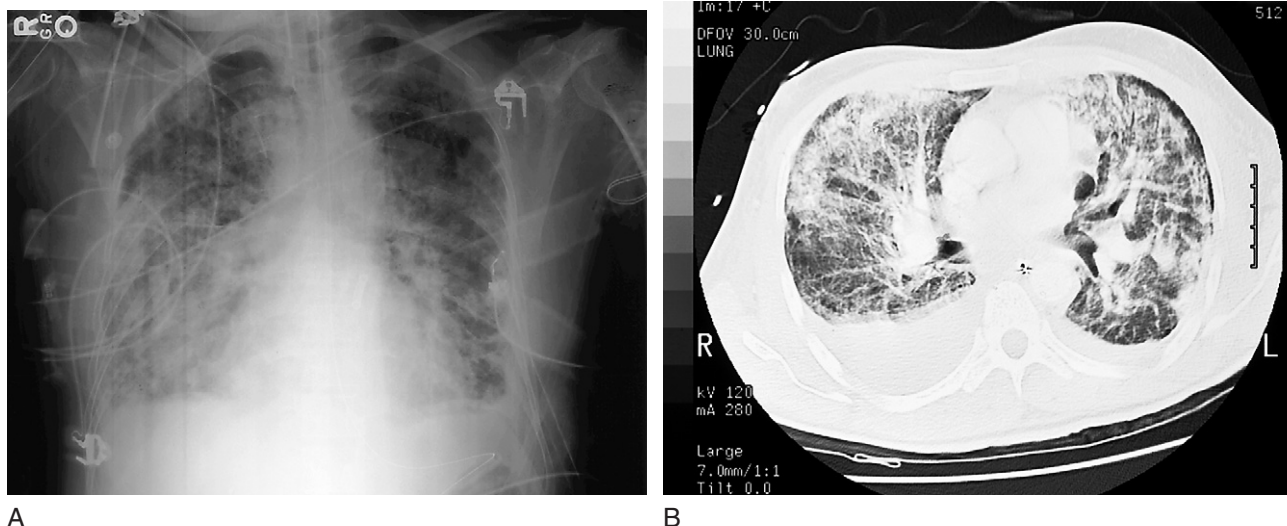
A, The chest radiograph of a 64-year-old man with acute respiratory distress syndrome secondary to bacterial pneumonia demonstrates patchy involvement of all quadrants. B, A computed tomography scan demonstrates diffuse heterogeneous involvement of all lung fields and the presence of bilateral pleural effusions.
